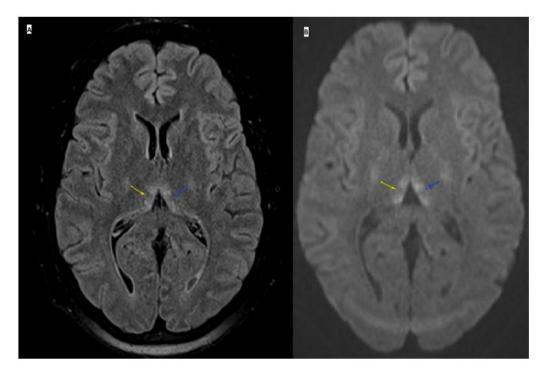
MRI of orbits with and without contrast showing increased T2 fluid-attenuate inversion recovery (FLAIR) signal (A) and increased signal on diffuse weighted imaging (DWI) sequences (B) without reduced apparent diffusion coefficient (ADC) signal (not shown) in the bilateral dorsomedial thalami as well as minimally increased T2 FLAIR signal in the periaqueductal gray matter (not shown).
